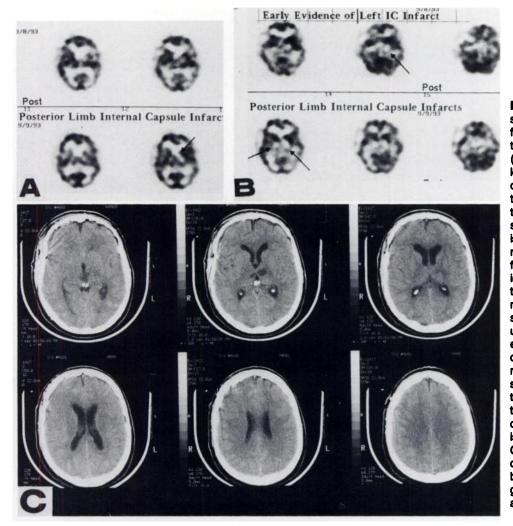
(A and B). Transaxial SPECT for Patient 1 on the first postoperative day (top) and the second postoperative day (bottom). Note early evidence of left posterior limb of the internal capsule and thalamic infarcts on the top, middle image denoted by the arrow in (B). Images on Day 2 show more convincing bilateral ischemic injuries denoted by arrows. Defect in the right inferior fronto-temporal region in the last image on the upper row of (B) is the operative site. There is also mild left orbito-frontal hypoperfusion. Mildly increased soft-tissue uptake on the right is reflective of expected scalp activity from recent craniotomy. There is a slight right-to-left head tilt on the second study, but the defects seen in multiple views are not caused by the tilt (software unavailable for tilt correction or more precise coreqistration). (C) Noncontrast head CT scan performed on the same day as the second SPECT shows bilateral hypodensities, left areater than right, in the thalami and adjacent white matter.
